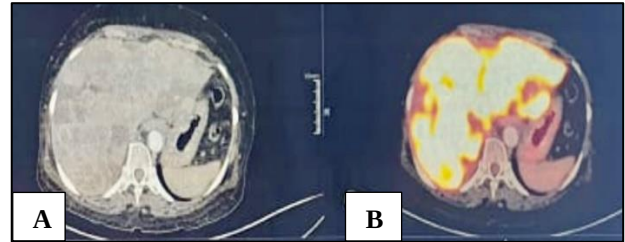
(A and B): Liver is enlarged with multiple enhancing lesions in both lobes of the liver (SUV max - 11.4).
